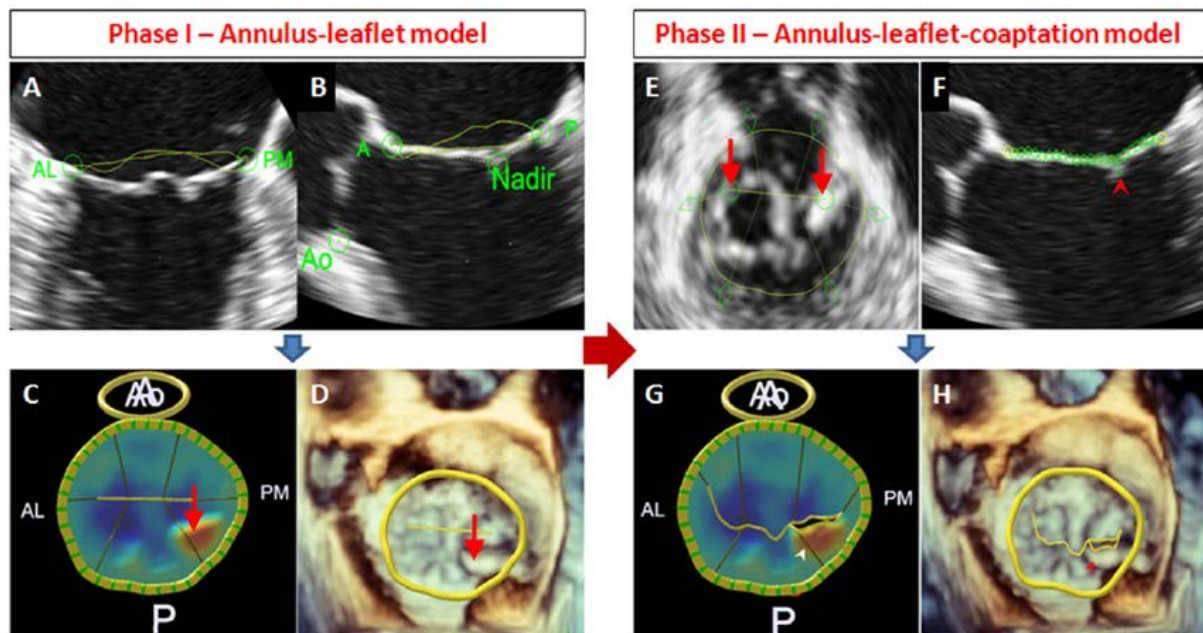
Mitral valve quantification using anatomical intelligence in three-dimensional transesophageal echocardiography. A-D: Anterolateral (AL), posteromedial (PM), anterior (A), and posterior (P) mitral annulus points; aortic annulus (Ao); and coaptation (Nadir) points were tagged in the 2 orthogonal long-axis planes (A and B). Then, a color-coded 3-dimensional topographical surface is displayed with leaflet billowing above the annular plane (minimal surface) depicted red (arrow) and leaflet below the annular plane blue (C). The surgeon's view of mitral valve with automatically tracked annular contour (yellow line) superimposed on the volume-rendered image showing P3 scallop billowing (arrow) (D). E-H: the two commissures were marked in the short-axis plane (arrows) (E). Points of leaflet coaptation (arrow) were marked plane by plane from commissure to commissure to delineate the line of coaptation (F). The final mapping is displayed as a color-coded topographical map (G) and annular contour (yellow line) with the line of coaptation superimposed on the volume-rendered image showing P3 scallop prolapse with involvement of the leaflet edge (arrow) (H).
